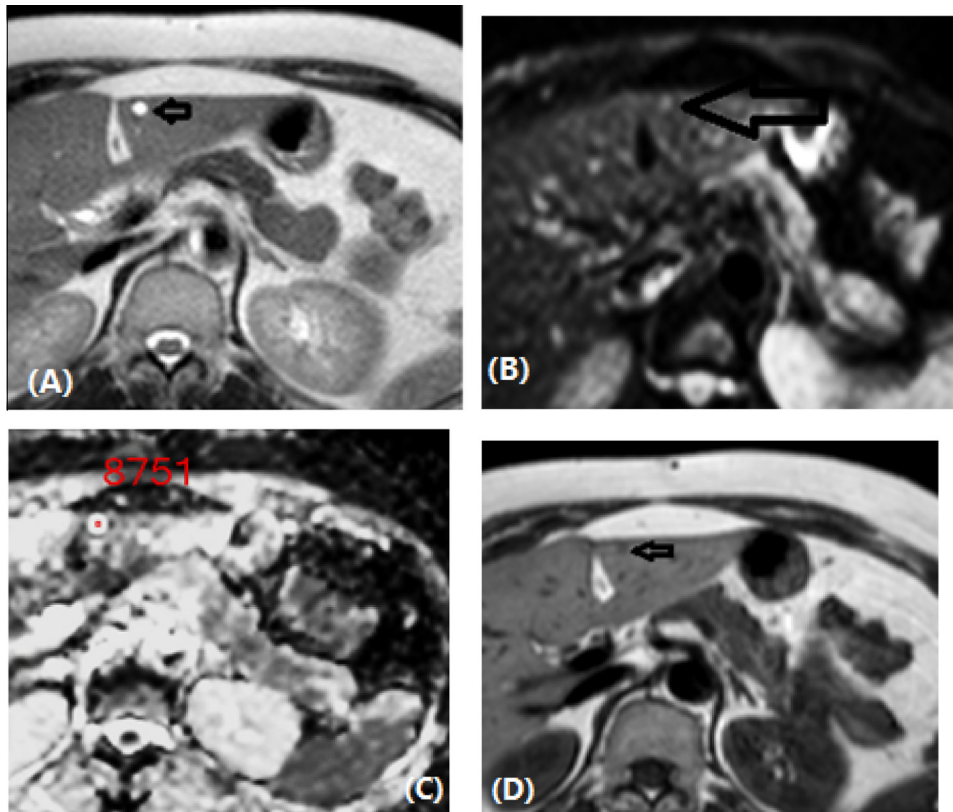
Hepatic small simple cyst in a 45 year-old female patient. (A) Axial T2-weighted image discloses a tiny hyperintense lesion in the left lobe (arrow). (B) Axial single-shot echo-planar DW image ($b = 600$), the lesion shows T2 shine-through rather than restricted diffusion (some signal loss occurring) (arrow). (C) On the ADC map, the lesion is markedly hyperintense with high ADC value ($3.1 \times 10^{-3} \text{ mm}^2/\text{s}$) (asterisk). (D) Axial T1-weighted image, the hypointense left hepatic lobe cyst (arrow) is more difficult to see.
